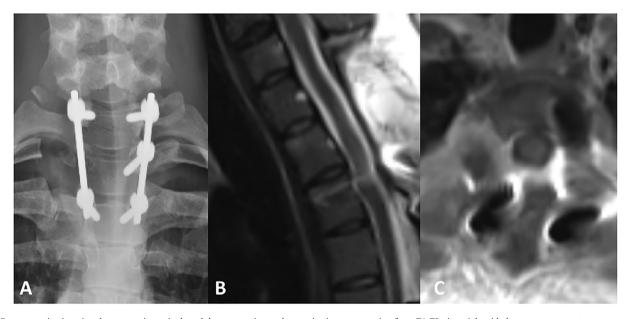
Post-operative imaging demonstrating spinal cord decompression and posterior instrumentation from T1-T3 via a right-sided costotransversectomy approach. A. AP radiograph B. Sagittal T2-weighted MRI C. Axial T1 post-contrast MRI at the level of the T2 vertebral body.
